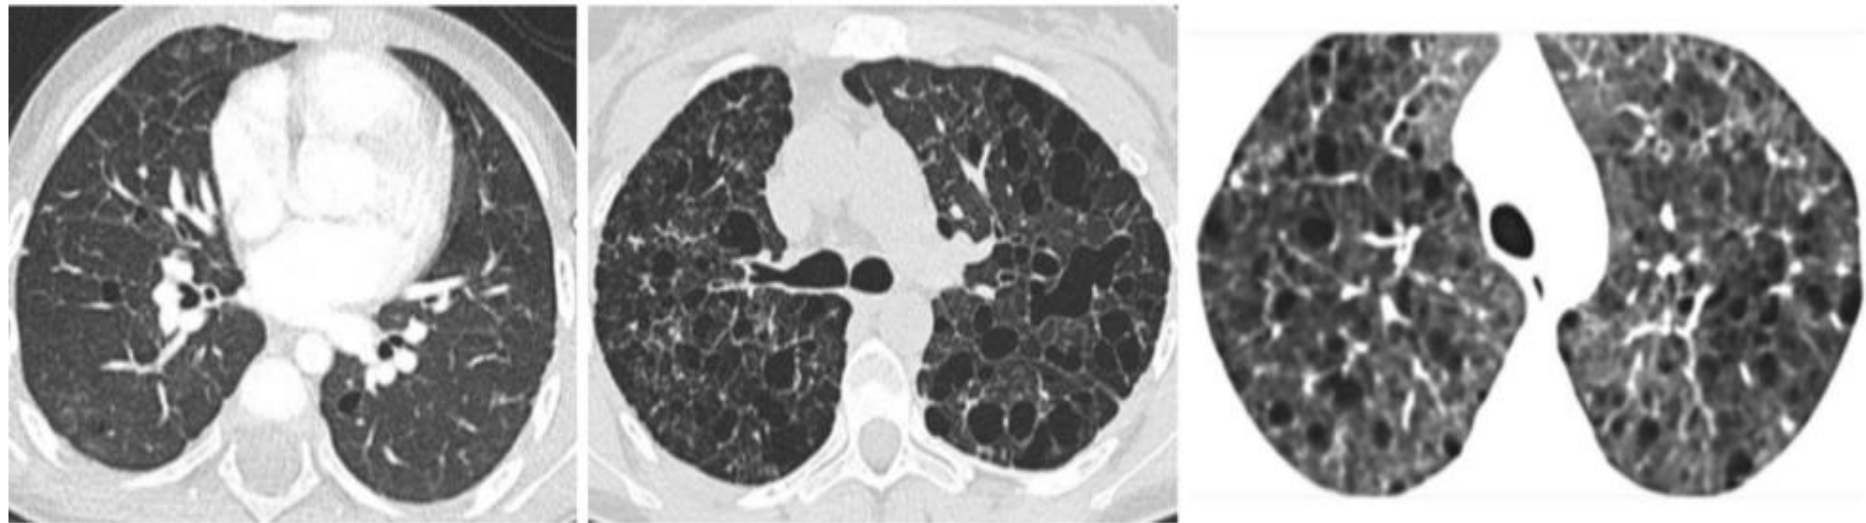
Three patients with differing degrees of pulmonary involvement in pulmonary Langerhan's cell histiocytosis. CT demonstrates multiple thin walled irregular cystic air spaces
